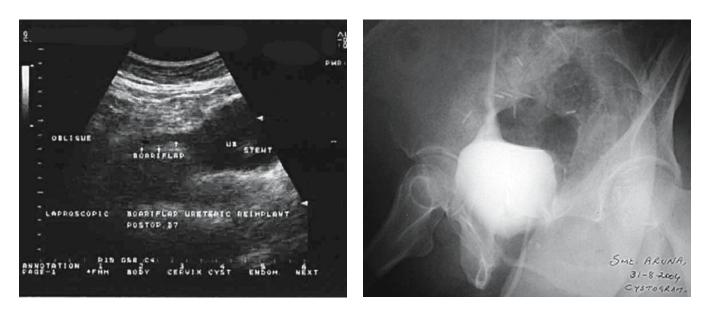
Postoperative sonogram on day 7 shows the Boari flap with the stent in situ
